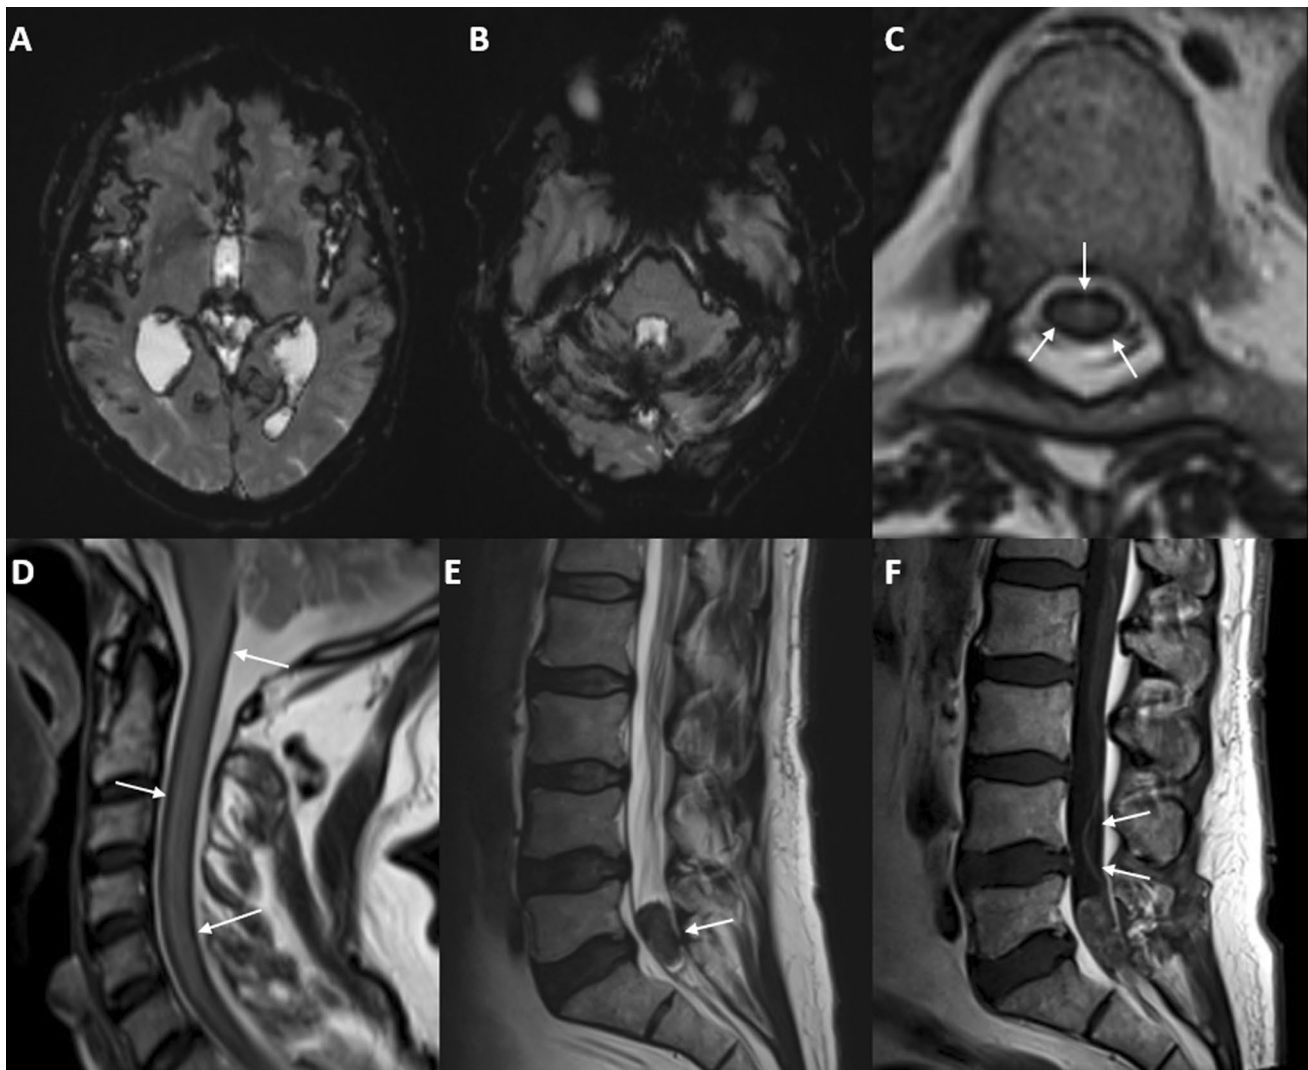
Brain and full spine MRI. a, b Axial gradient echo T2*-weighted images showing a rim of hypointensity all around the cerebellum, brainstem, and interhemispheric and sylvian fissures. c, d Axial (c) and sagittal (d) T2-weighted images revealing hypointense
